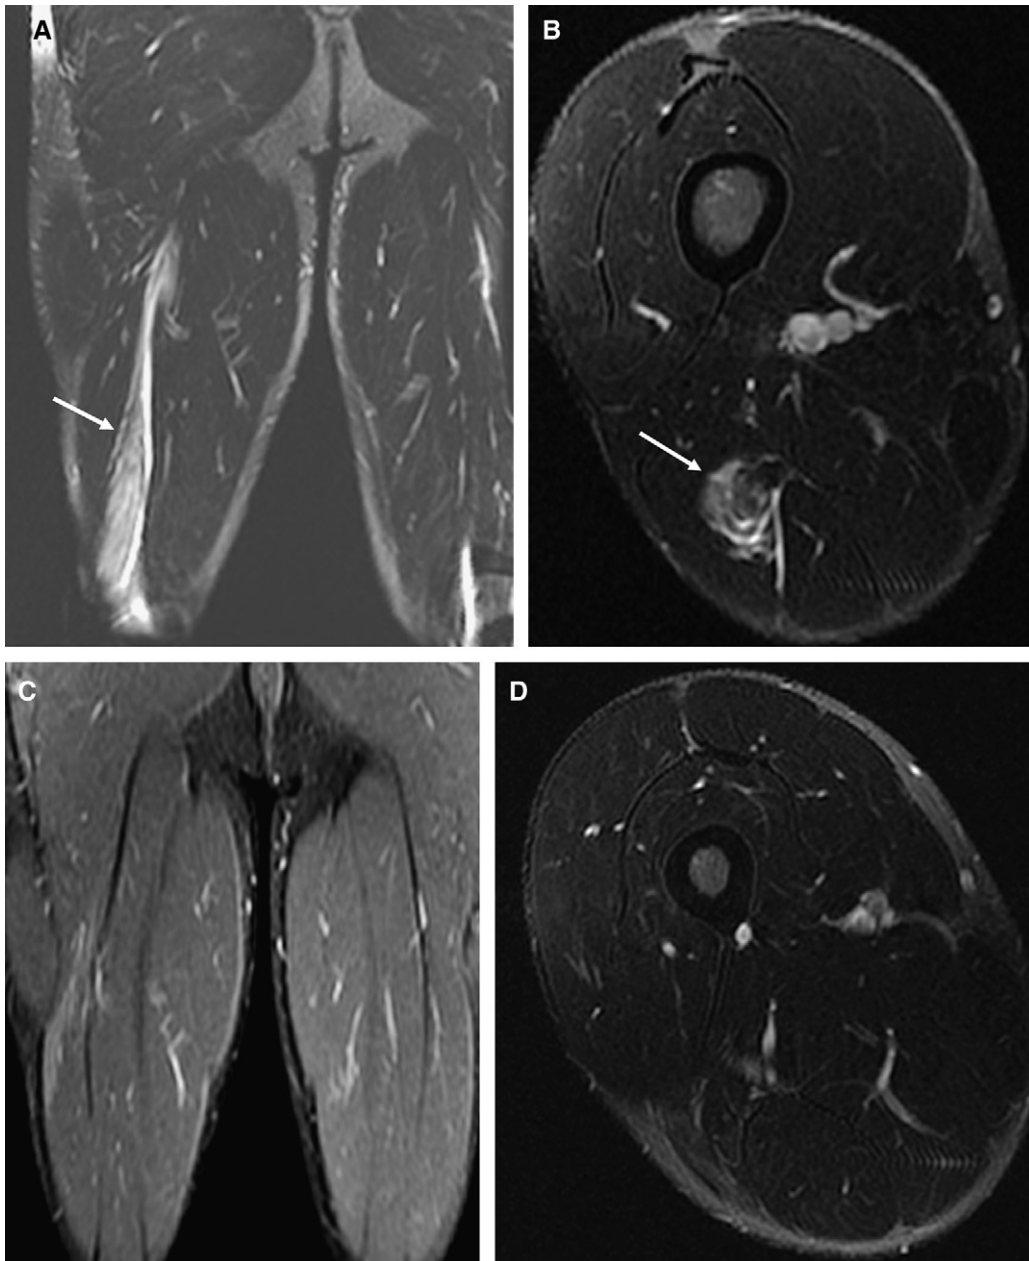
Muscletendinous junction injury of the long head of the biceps. Axial and coronal fat-saturation fast spin-echo T2-weighted magnetic resonance imaging (A, B), demonstrating high-grade partial tear of the distal muscletendinous junction (white arrows) of the long head of the biceps. (C, D) Interval resolution (5-month follow-up) of the previously demonstrated oedema and fluid in and adjacent to the biceps femoris and semitendinosus muscles with healing and scarring without progression; the patient returned to professional basketball.
